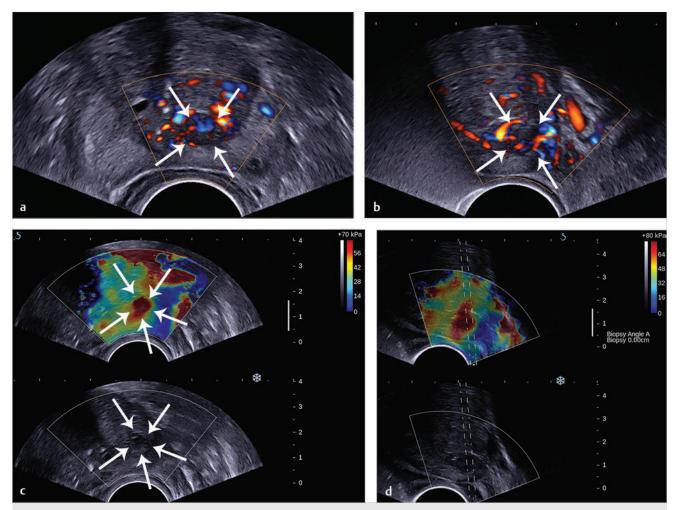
The additional value of shear wave elastography (SWE) for prostate cancer diagnosis and biopsy. (a,b) Prostate B-mode and directional power Doppler TRUS did not detect any lesion in the peripheral zone; a single hypervascular nodule was seen in the transition zone sitting next to the posterior surgical capsule and exhibited some strong hypervascularity (*white arrows*) in the transverse plane (a) and the sagittal plane (b). (c) During the detection scan from base to apex, SWE revealed a very stiff nodular area (red pattern) in the peripheral zone at mid-gland level. The area was previously seen at B-mode imaging as a pseudo-cystic hypoechogenic area and was not initially considered as a potential target. (d) SWE-targeted biopsy inside this lesion confirmed the presence of a Gleason score 6 adenocarcinoma. All other cores were negative.
